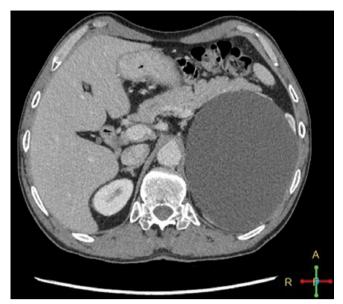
Axial contrast-enhanced computed tomography. On the left, note a huge fluid collection with smooth outlines, impinging on the tail of the pancreas (interpreted as a cyst of the tail of the pancreas)
